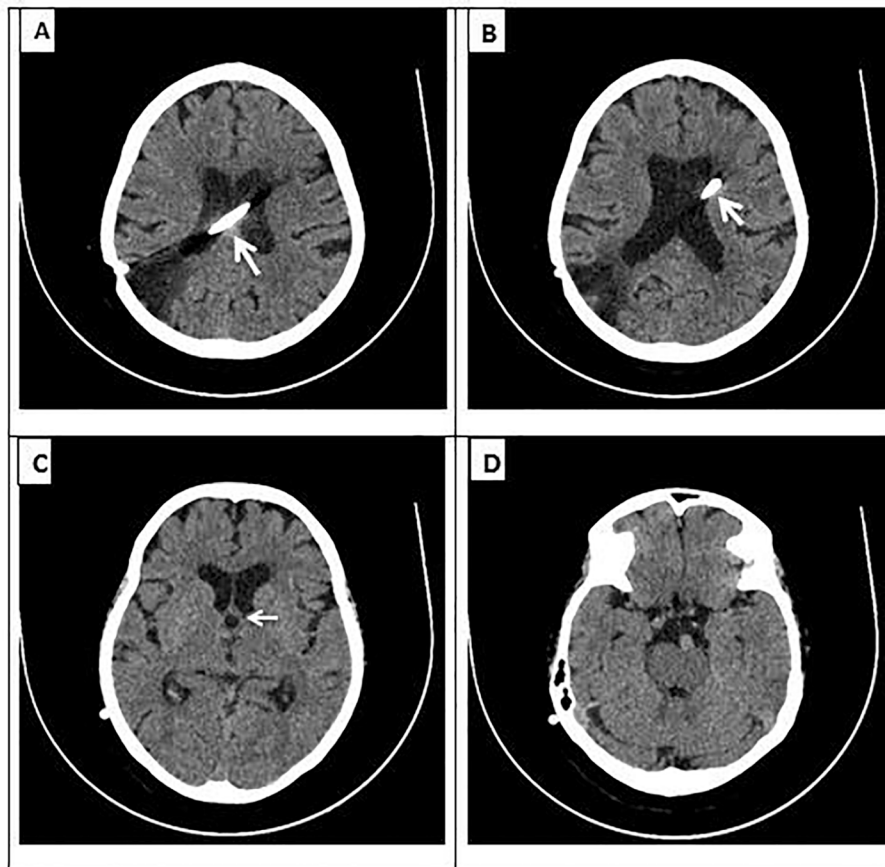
Follow up CT brain image taken after 1 year with VP shunt in situ (shown in panel A and B marked with white arrows). Ventricular size has reduced with no significant periventricular hypodensities. 3rd ventricle marked in panel C with white arrow.
